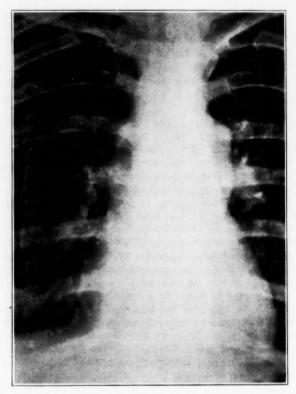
Anteroposterior roentgenogram of chest, showing tumor in the upper portion of the mediastinum.
